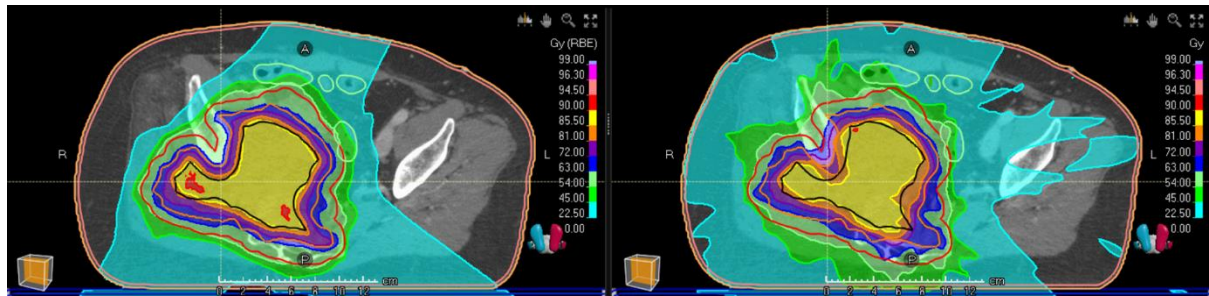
Proton (left)- or X-ray (right; VMAT) therapy including partial tumor boosting for a patient with inoperable STS. The proton plan yields high target conformity and a greater dose fall-off compared to the X-ray plan.
